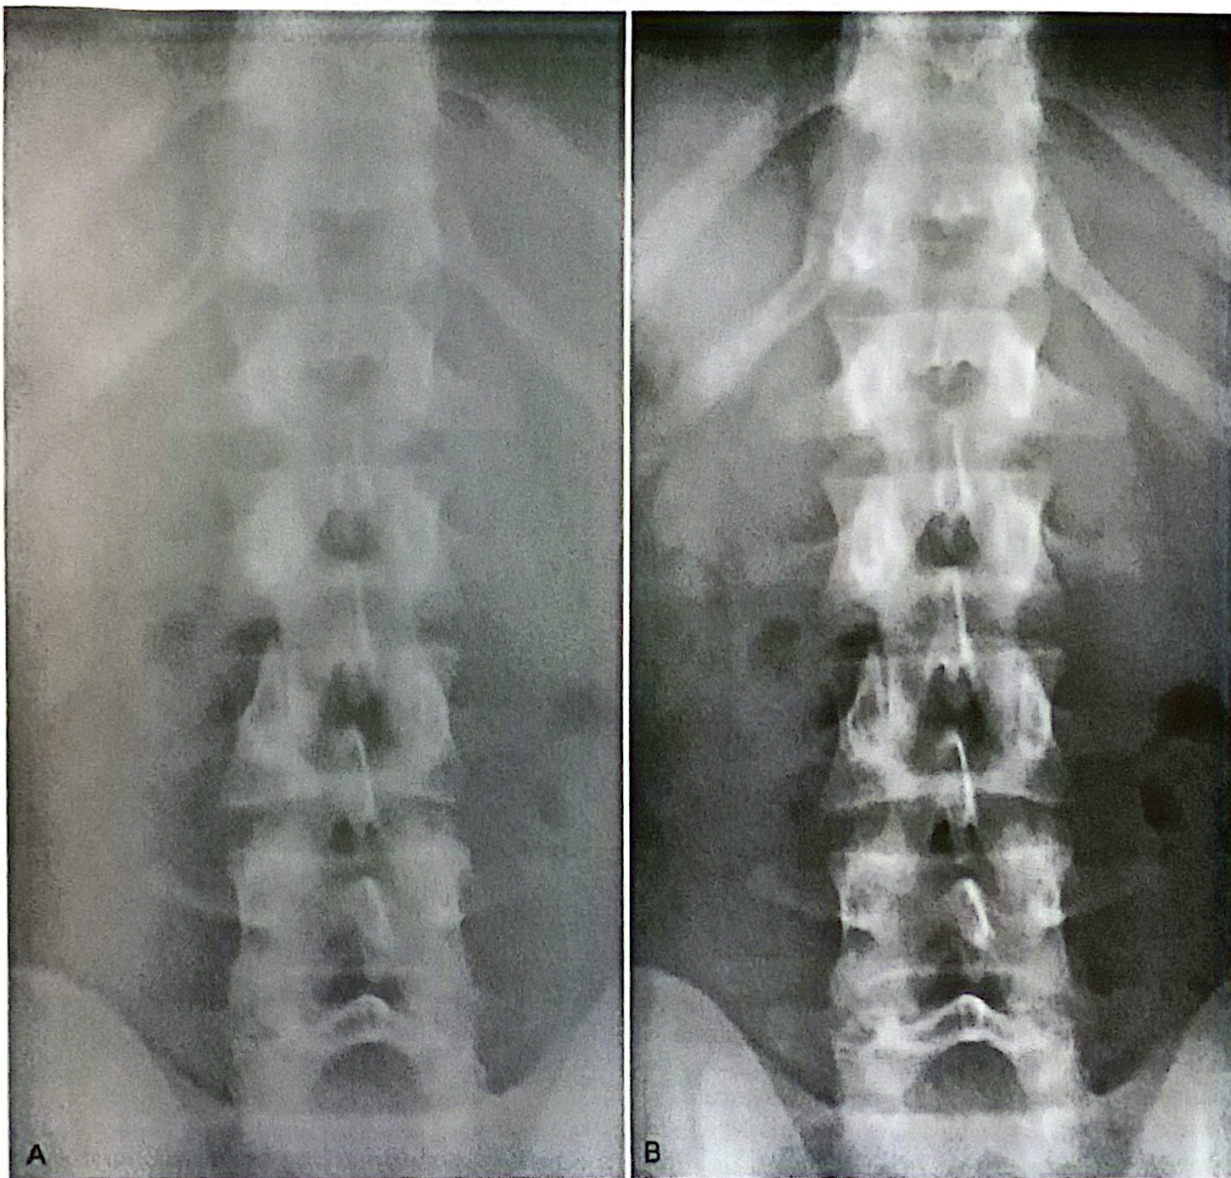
(A) AP lumbar spine image demonstrating poor (low) radiographic contrast. (B) This image demonstrates appropriate radiographic contrast.
